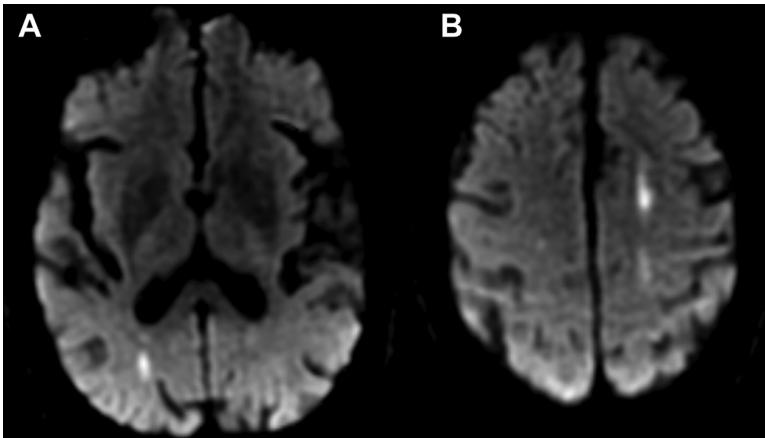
Diffusion-weighted magnetic resonance imaging showing acute watershed infarcts in right (A) and left (B) hemispheres.
